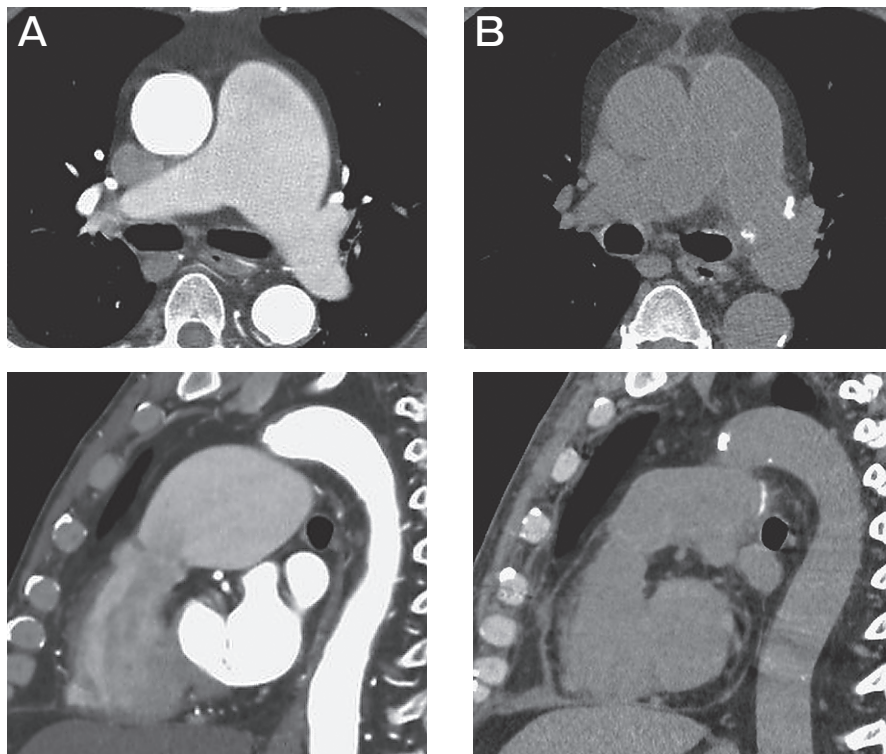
Postoperative CT shows replacement of the PA with a prosthetic graft, in comparison with the native PA observed on preoperative contrast-enhanced CT. A, Preoperative CT with contrast; B, Postoperative CT.
